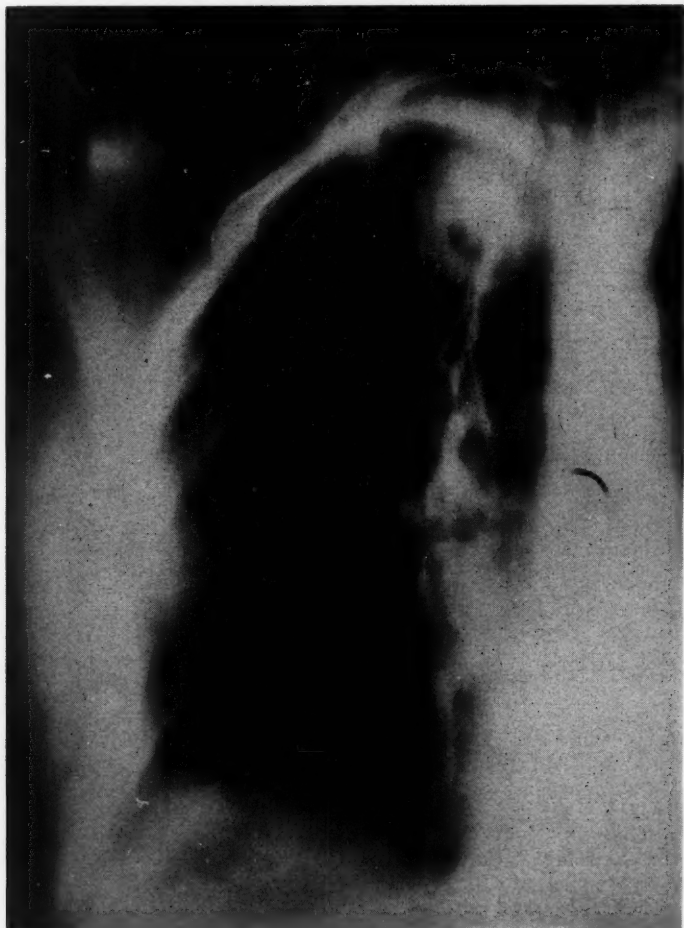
Tomogram, 12-3-53, delineates right upper lobe disease and cavity better than conventional roentgenogram of 11-19-53. Patient had become resistant to PAS; INH was added to SM-PAS regimen on 12-18-53, and right upper lobe disease resected 5-17-54.
